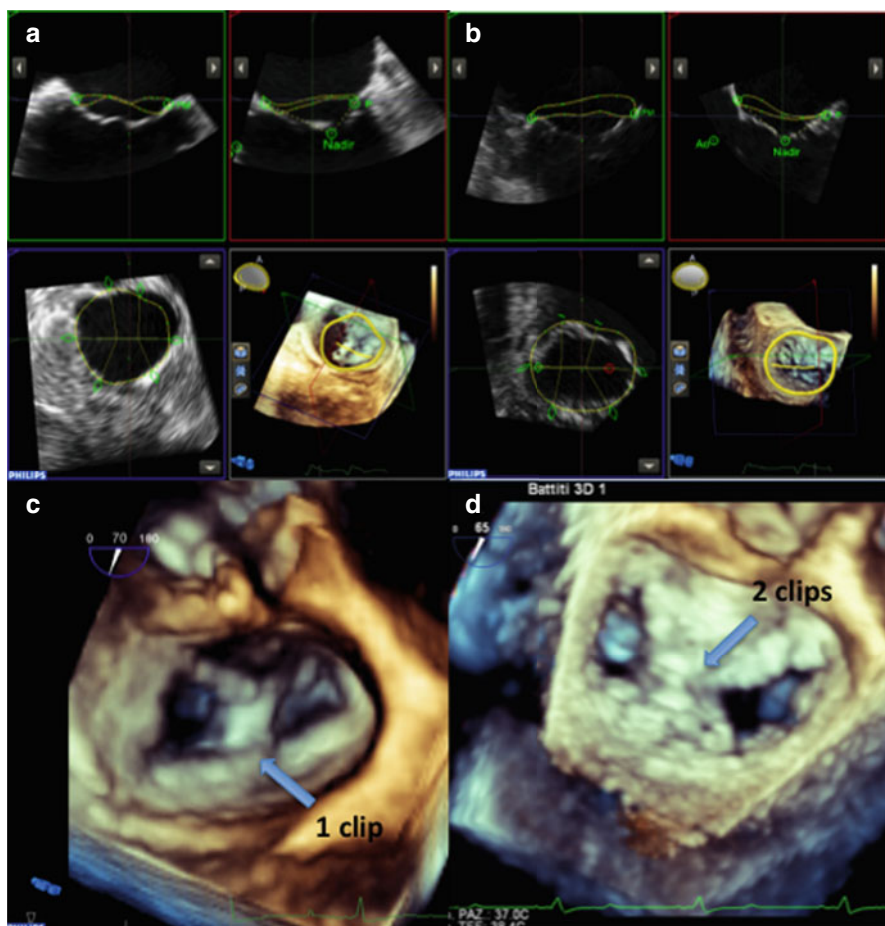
Transoesophageal three-dimensional echocardiographic reconstruction of the mitral valve annulus in a woman (a) and in a man (b) affected by functional mitral regurgitation. The mitral valve quantification showed smaller annulus dimensions in the woman compared to man. Due to a smaller annulus, the woman was treated with 1 clip (c), while the man with 2 clips (d)
